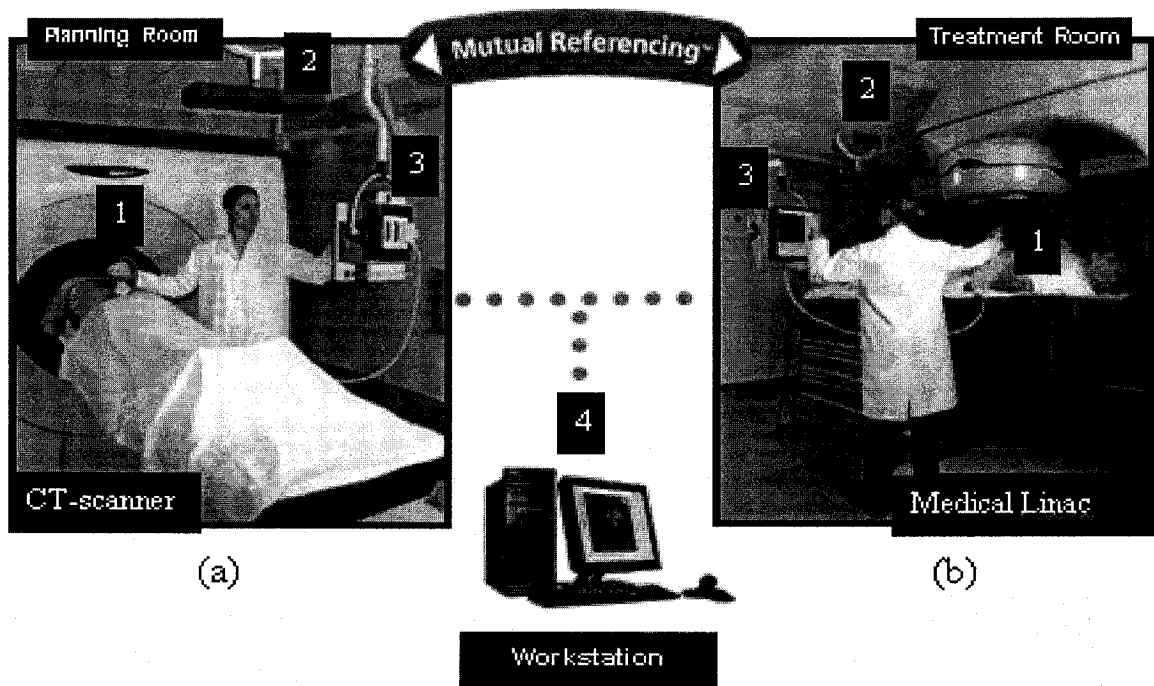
RES system located in (a) the CT room and (b) the treatment room. Each system includes its own (1) US probe, (2) motion tracking system and (3) image acquisition system. To visualize and analyze volumetric information acquired in 3D a workstation (4) is shared between the rooms. [Courtesy of Resonant Medical Inc].
